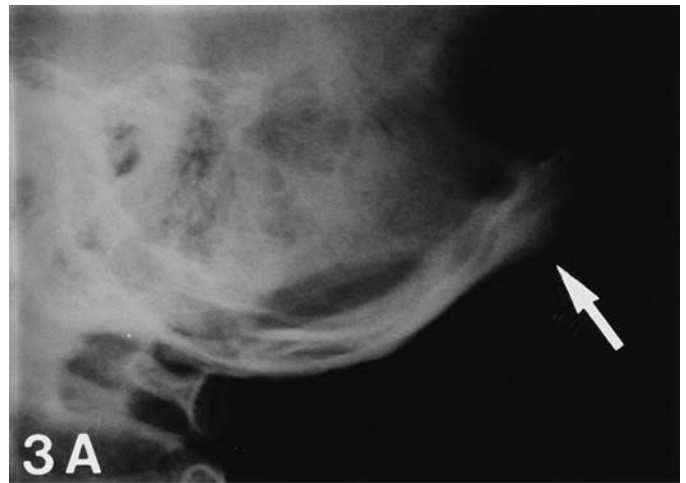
Crest type (Type 2) of the external occipital protuberance (arrow). A) Lateral cranium radiograph. B) Dry skull photograph.
